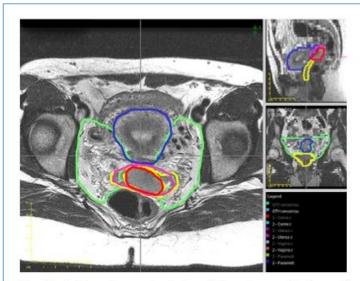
Axial and reconstructed sagittal and coronal views of T₂-weighted MR images from a clinical contouring case showing 95% agreement contours for GTV (red), cervix (pink), vagina (yellow), parametria (green), and uterus (blue).
